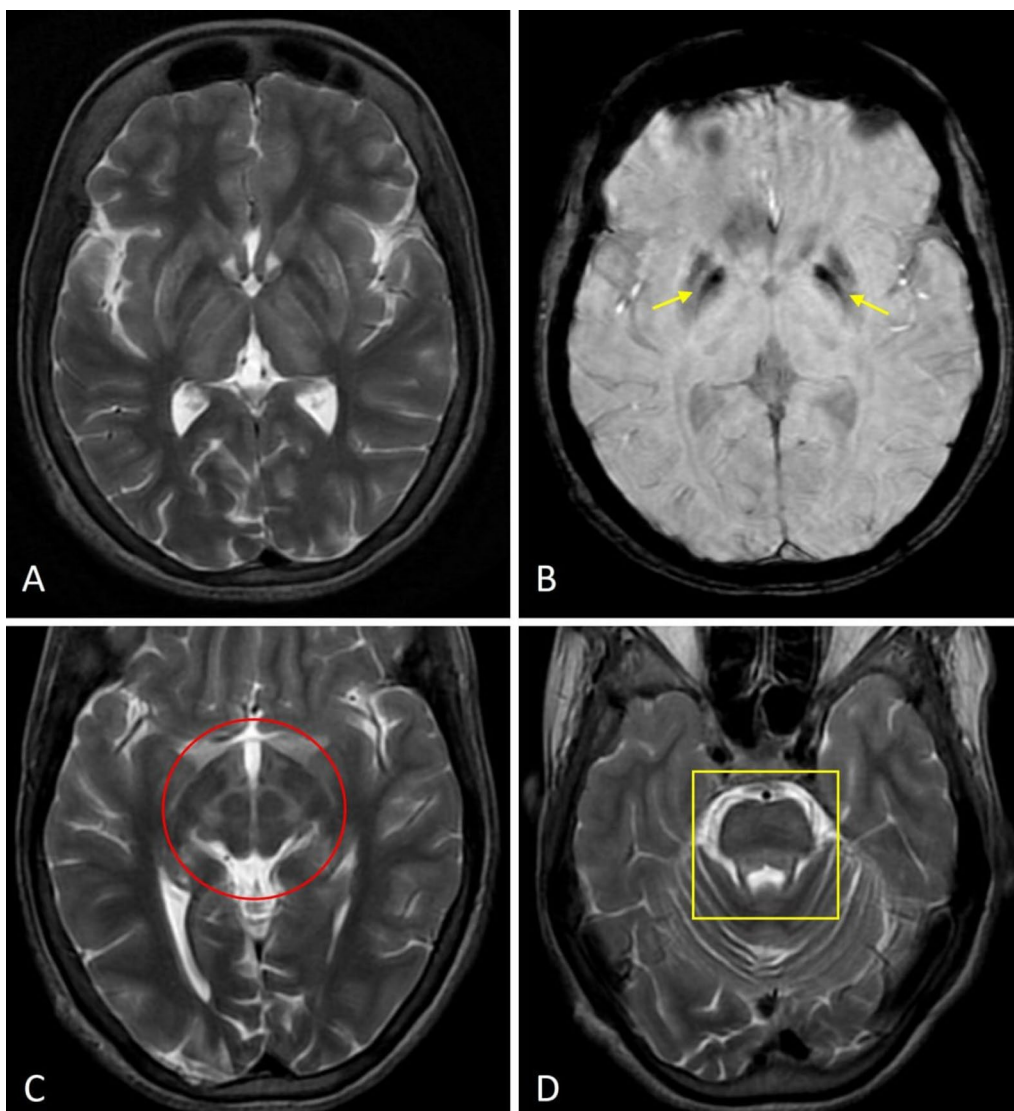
Axial T2 weighted MR image (A) shows symmetrical hyperintensity in bilateral caudate, putamen and thalami with bright claustrum sign. Symmetrical hypointensity is noted in bilateral globus pallidi. Axial SWAN MR image (B) shows symmetrical areas of blooming in bilateral globus pallidi (yellow arrows). Axial T2 weighted MR image at the level of midbrain (C) and at the level of pons (D) shows "face of giant panda sign" (red circle) and "face of miniature panda sign" (yellow box) respectively
